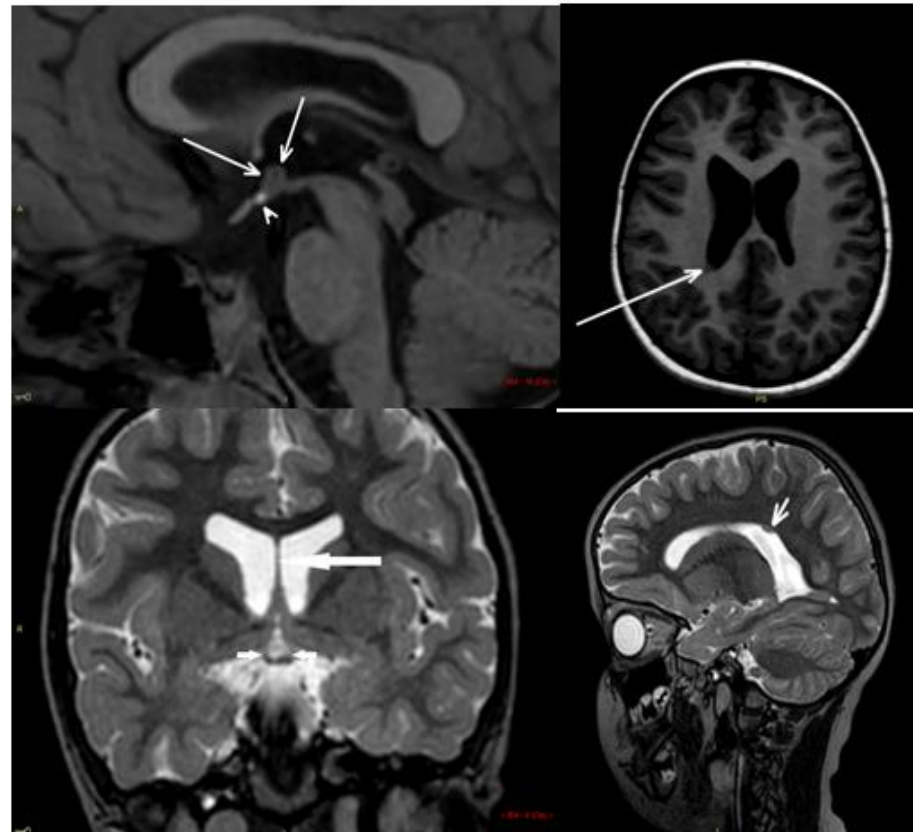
MRI of Patient with IHA + EPP+ optic nerve hypoplasia
